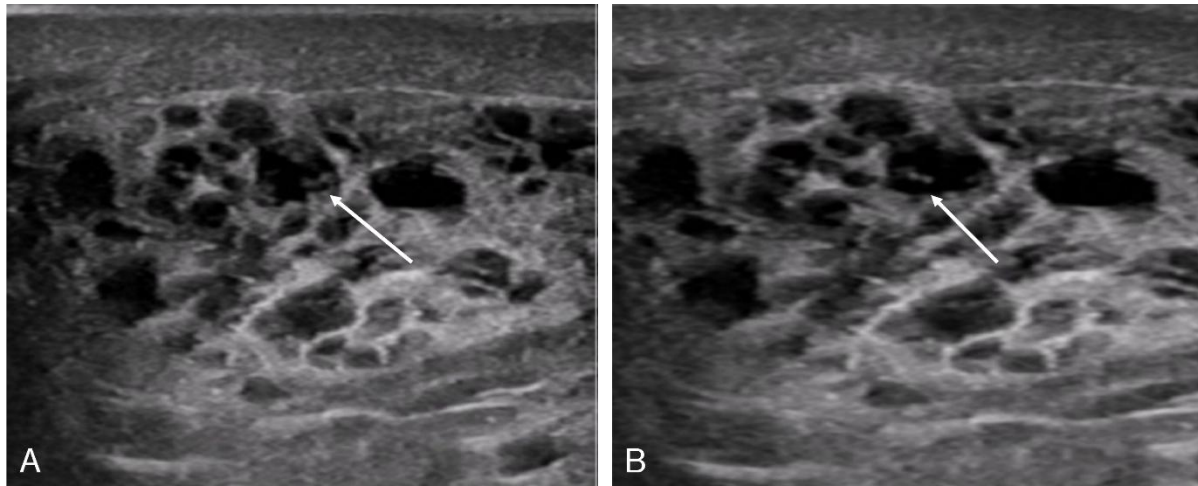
(A, B) High-resolution grayscale ultrasound images of the right spermatic cord showing multiple dilated lymphatic channels containing curvilinear, echogenic, undulating structures. These mobile elements represent live microfilariae, demonstrating the characteristic filarial dance sign
